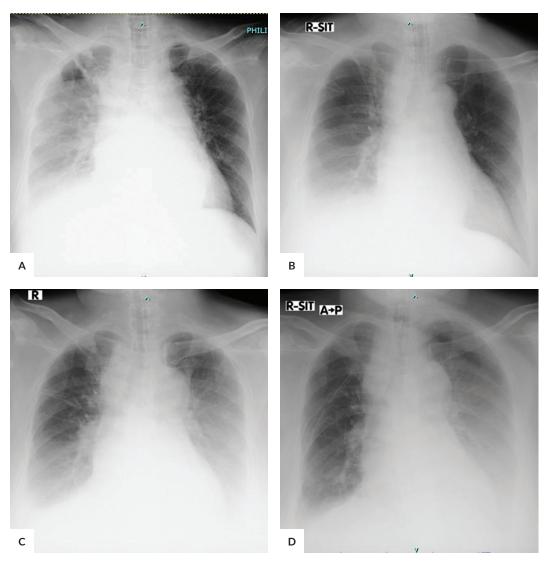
Serial chest x-ray done to show pleural effusion at right hemithorax. (A) Chest x-ray was taken during admission with noted pleural effusion at the right hemithorax. (B) Chest x-ray was taken after thoracentesis at right hemithorax with 400cc pleural fluid output. (C) On 6th day, chest x-ray showed still with effusion at the right and new onset of effusion at the left. (D) Chest x-ray done post-CTT insertion at the right and noted progression of effusion at the left.
